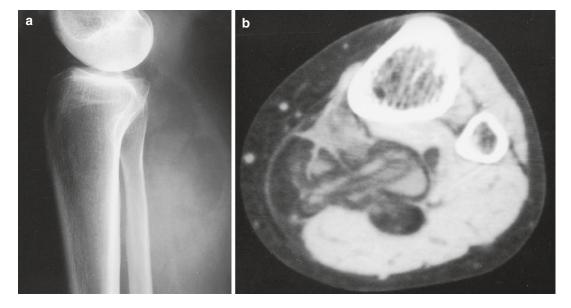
Low-grade liposarcoma arising behind the knee joint in a 55-year-old woman. (a) Plain radiograph. (b) Computed tomography (CT). Fat density areas are visible
